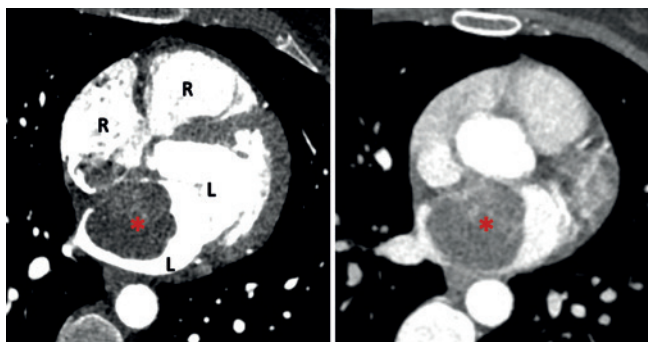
A and B) Computed tomography (CT) cardiac images. Contrast enhanced axial CT scan showing inferior enhancement of the mass occupying most of the left atrium volume in keeping with myxoma. Red asterisk indicates the mass in the left atrium.
